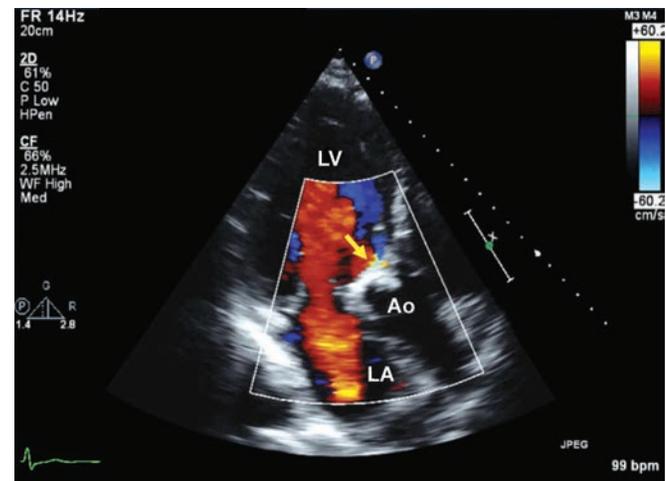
TTE apical long axis view with color Doppler demonstrates para-valvular leak (arrow).
